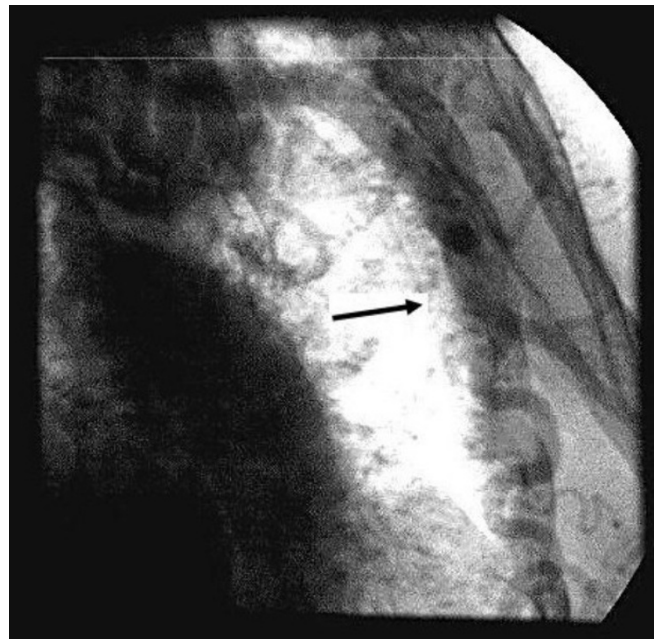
CT angiogram revealing severe stenosis of the aorta below the origin of the subclavian artery.
